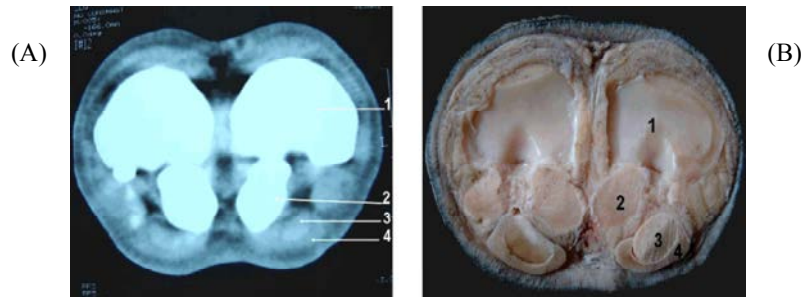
(A) Transverse CT image and (B) cross section at the level of fetlock joint. 1, the articular surface of the proximal extremity of the proximal phalanx; 2, proximal sesamoid bones; 3, deep digital flexure tendon enclosed in; 4, superficial flexure tendon.
